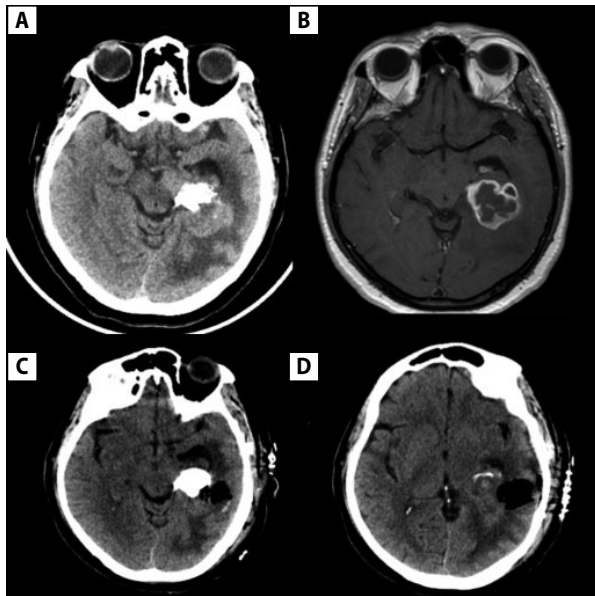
A and B. Pre-operative MRI and CT-scan showing intra-axial tumour with calcific mass; C and D. Post-operative CT-scan with surgical cavity and residual calcific portion (malignant glioma) without clots
